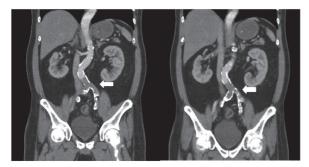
Abdominal computed tomography (CT) with contrast. Abdominal CT demonstrates near complete occlusion of the distal abdominal aorta with a large saddle embolism (arrow) overriding the aortic bifurcation extending to both common iliac arteries.
